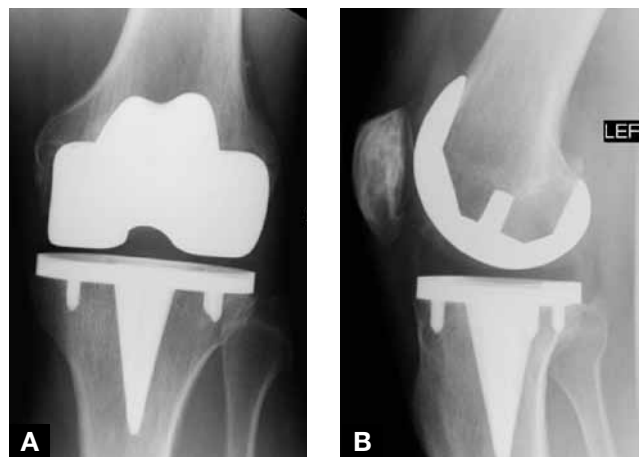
(A, B) At 9 years, radiographs of NK-II system with cementless fixation of femoral component and stemmed tibial baseplate without supplemental screws (other knee of patient in Figure 3).
